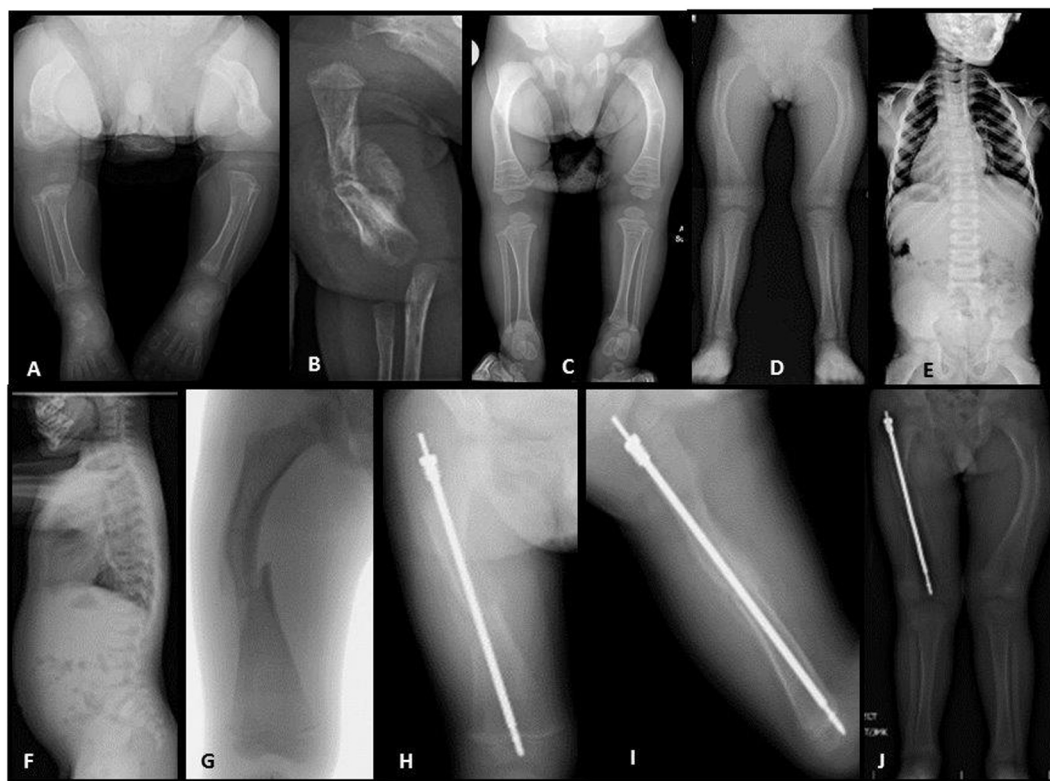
Radiographic images. Lower extremities (panel A) and right humerus (panel B) at 12 days of age. Lower extremities at 1 year of age (panel C) and 4 years 6 months (panel D). Anterior posterior (AP) (panel E) and lateral (panel F) thoracolumbar spine. AP of right femur fracture at 4 years 7 months (panel G). AP (panel H) and lateral (panel I) images obtained 8 weeks postoperatively demonstrating Fassier-Duval rod placement and healing of the fracture and osteotomy. Lower extremities at 5 months postoperatively.
